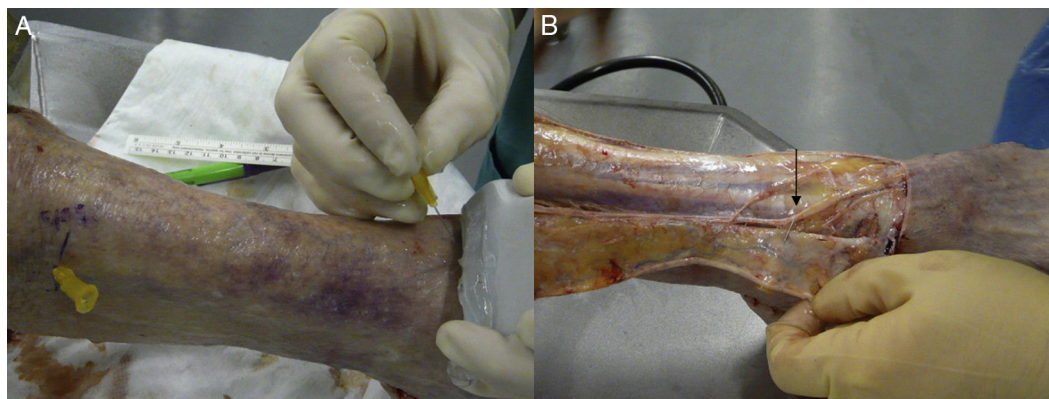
(A) Ultrasound marking of superficial peroneal nerve and (B) correlation with dissection findings.
